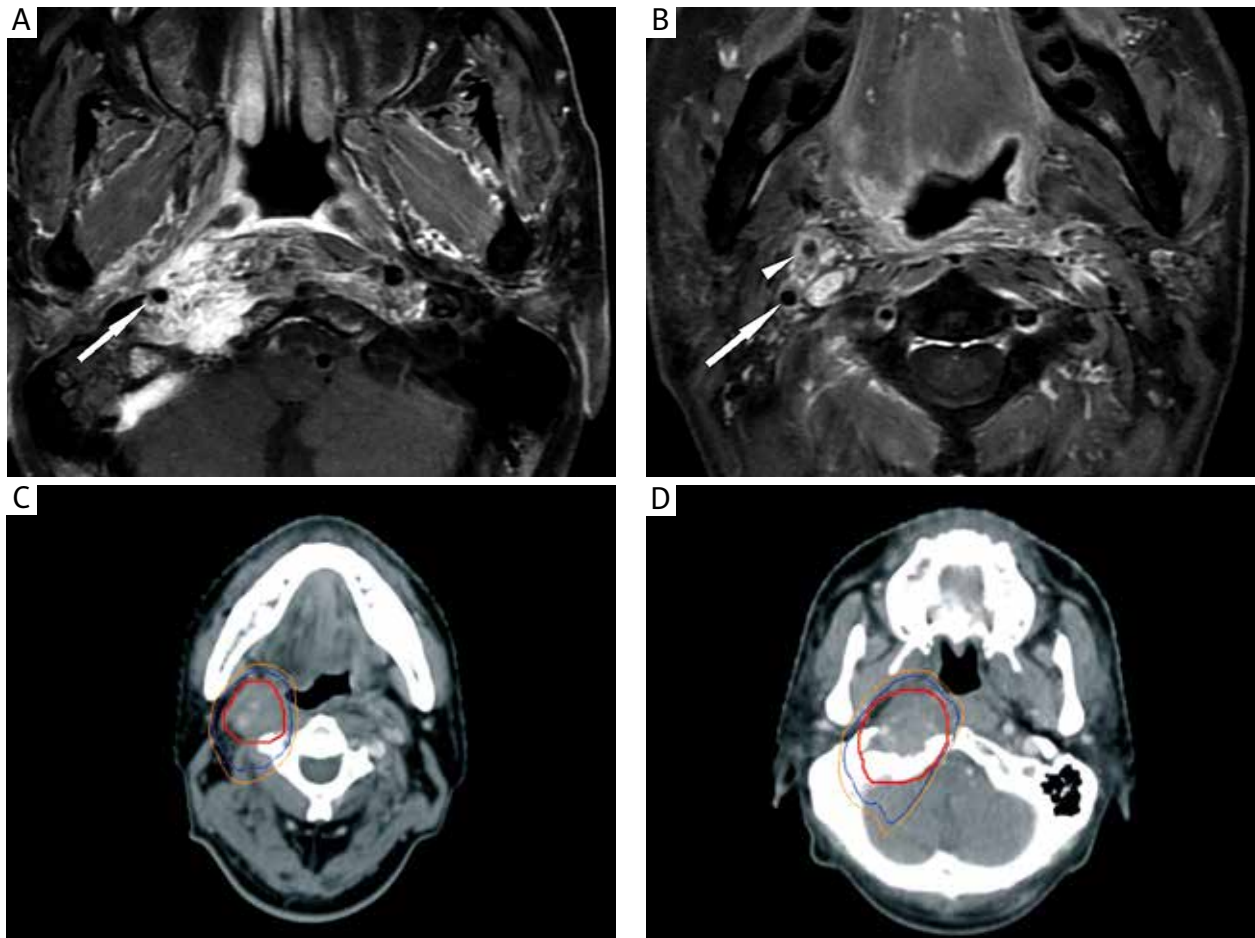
A) Irregular mass located on posterolateral side of right pharyngeal region was seen as hyperintense in MRI-T1WI before re-irradiation, involving the right pre- and paravertebral muscles and dura mater. Arrow indicates the mass surrounding the internal carotid artery. B) Level of branching of lingual artery from external carotid artery: Heterogeneous signal in tissue around the lingual artery (arrow head), the obvious intensified mass after enhancement was seen on the posteromedial side. The internal carotid artery is located posterolaterally (arrow). C) The lingual artery level dosage distribution curve. Red line: Gross tumor volume (GTV). Yellow line: 100% isodosage curve. Blue line: 95% isodosage curve. The lingual artery and the internal carotid artery received a dose no less than 100%. D) Dosage distribution curve on the mastoid process level: the intracranial segment of the internal carotid artery is surrounded by the tumor
